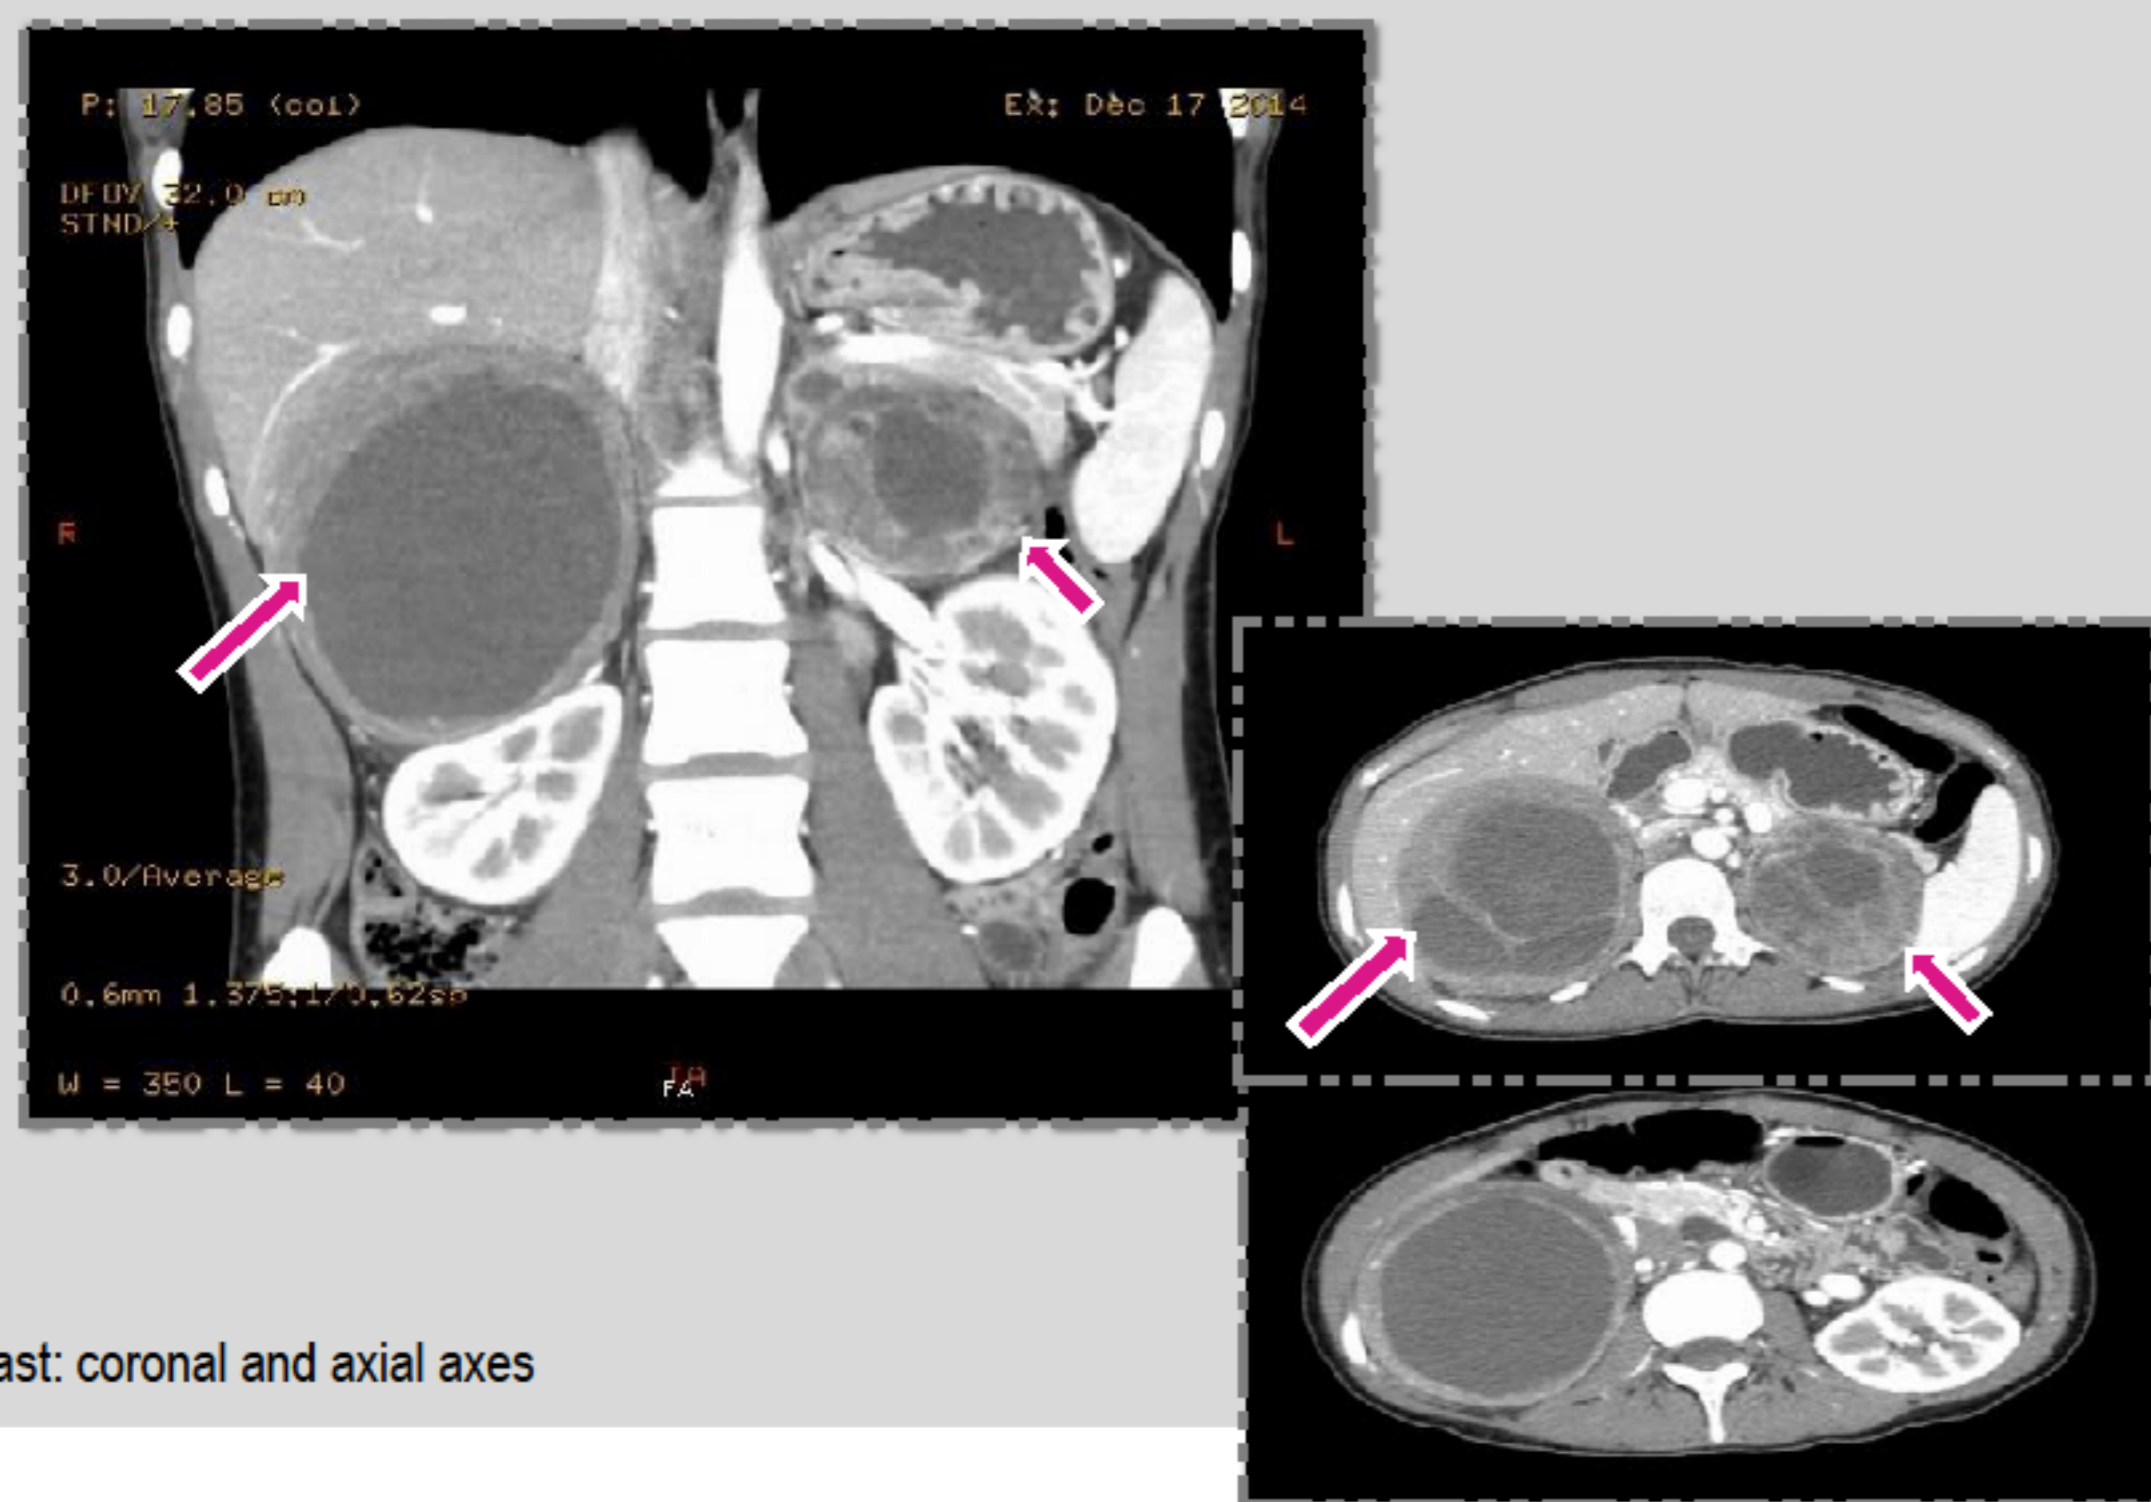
Abdominal CT, with contrast: coronal and axial axes
